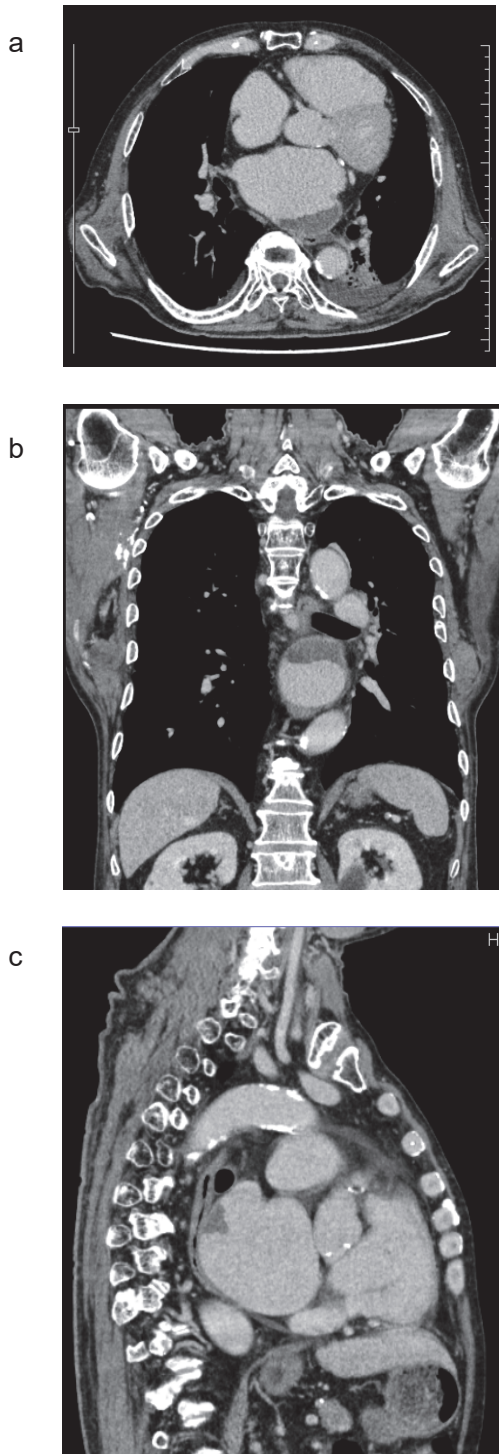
A contrast-enhanced computed tomography image of the chest showing a thrombus in the posterior wall of the left atrium ([A] axial view, [B] coronal view, [C] sagittal view)
